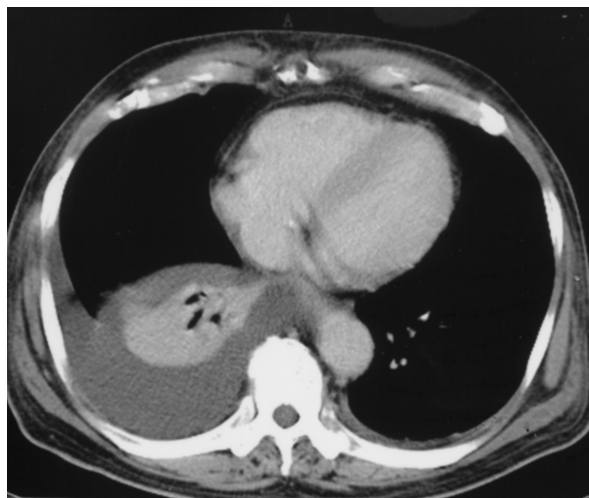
Chest computed tomography shows right pleural effusion and atelectasis (case 1)
